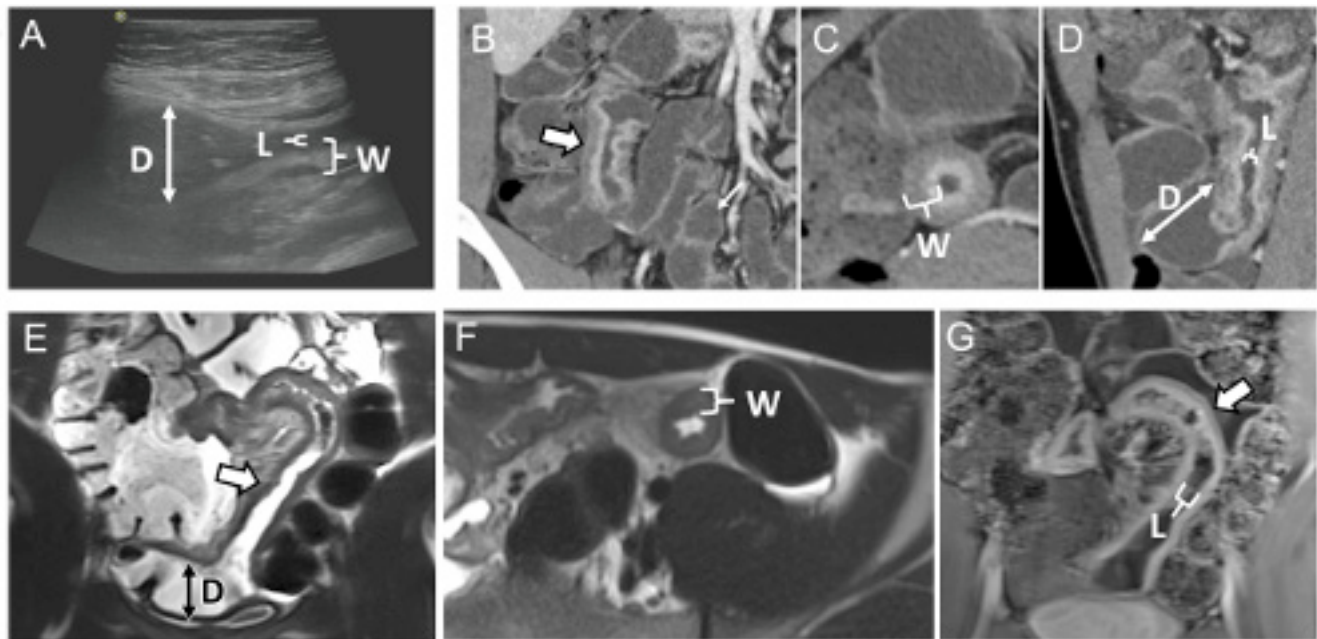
Transabdominal ultrasonography, CT and MR enterography demonstrating a distal ileal stricture. (A) Ultrasound image depicting the three core items for stricture diagnosis wall thickness (W, *bracket*), luminal narrowing (L, *bracket*) and prestenotic dilation (D, *double arrow*). (B–D) CT enterography demonstrating a distal ileal stricture with imaging findings of active inflammation and partial small bowel obstruction. (B) Coronal image demonstrating a distal ileal stricture with wall thickening, luminal narrowing and mural stratification and hyperenhancement (*large white arrow*). Active inflammatory Crohn's disease is also present in the terminal ileum (*arrowhead*), as is a short segment jejunal stricture (*small white arrow*). (C) Enlarged axial image through distal ileal stricture better demonstrates luminal narrowing and increased wall thickness (W, *bracket*). (D) Sagittal image through distal ileal stricture shows prestenotic bowel dilation (D, *arrows*) and luminal narrowing within the stricture (L, *bracket*). (E–G) MR enterography demonstrating a distal ileal stricture with imaging findings of active inflammation. (E) Coronal half-Fourier single-shot fast spin echo (HASTE) shows ileal stricture with wall thickening and luminal narrowing (*large white arrow*) with upstream dilation (D, *arrows*). (F) Axial HASTE shows cross section through the stricture demonstrating increased wall thickness and how wall thickening is measured (W, *white bracket*). (G) Postcontrast axial 3D volumetric interpolated breath hold examination (VIBE) shows wall thickening and mural stratification and hyperenhancement, indicating inflammation with luminal narrowing (L, *bracket*). The three core items for stricture diagnosis are increased wall thickness, luminal narrowing and prestenotic dilation. CTE, CT enterography; MRE, MR enterography.
